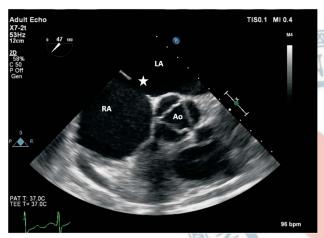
Transesophageal echocardiography is showing atrial septal defect. Ao, Aorta 116×84 mm; LA, left atrium; RA, right atrium.
